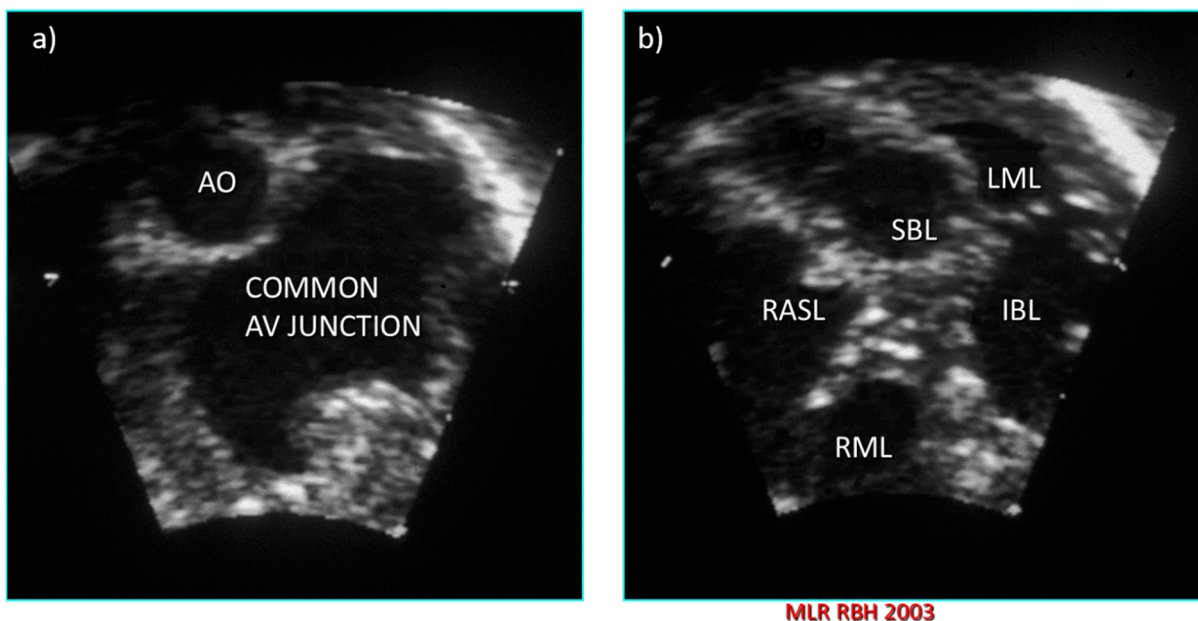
Subcostal left oblique short axis echocardiographic sections of the AV junction showing (a) the common atrioventricular junction and (b) the five leaflets of the common atrioventricular valve.
